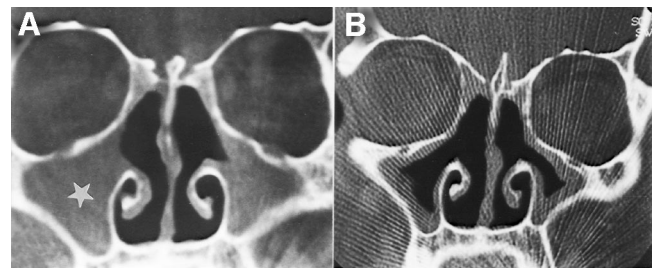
(A) On CT image, both maxillary sinuses of patient 1 are filled with swollen mucosa and inflammatory secretion (☆) as result of chronic mucositis. (B) Six months after RTSO of both sinuses with cumulative activity of 55 MBq ^{186}Re -colloid (each), CT follow-up showed significantly decreased mucous layer. However, follow-up another 14 mo later showed recurrent mucositis in right maxillary sinus, although patient still felt better than before RTSO (artifacts caused by dental implants).
